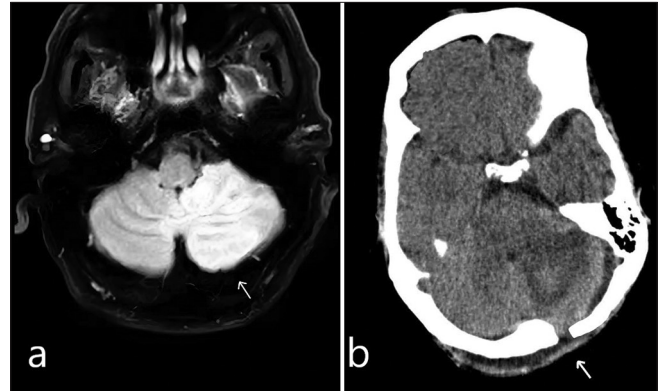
(a) Axial T1-weighted magnetic resonance imaging scan, the white arrow shows a cerebellar infarction with a measured volume of 7.8 cm³, as determined by the software (preoperative image). (b) Postoperative computed tomography scan demonstrating the removal of necrotic tissue. The white arrow shows the creation of an endoscopic fenestration.
